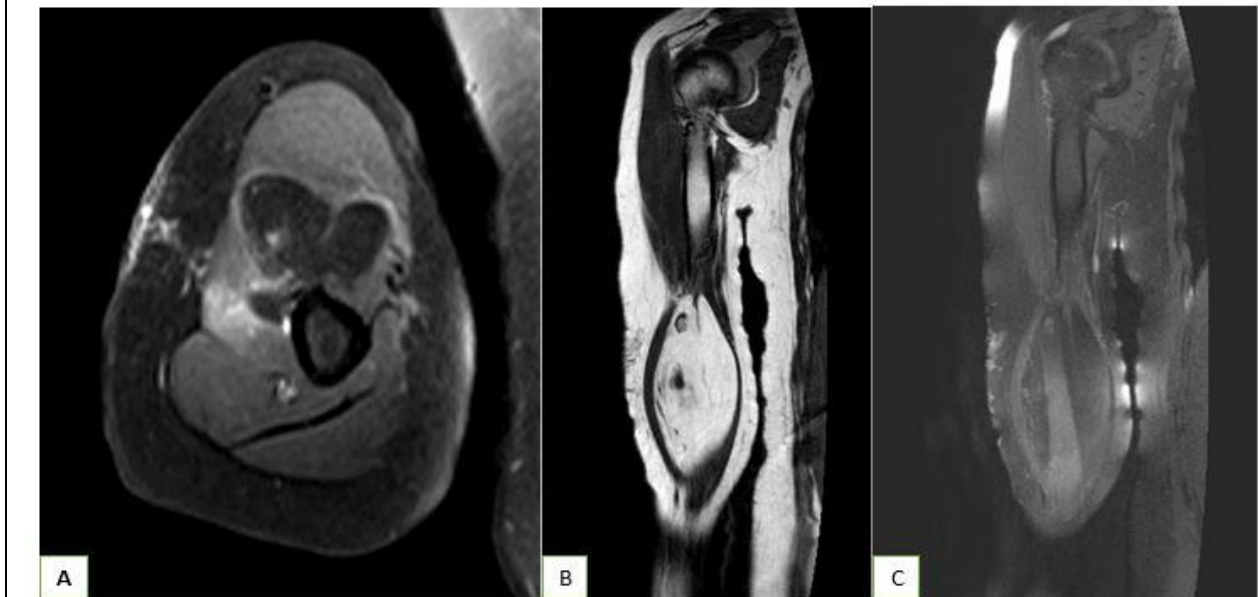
MRI Scan: Axial T2-weighted (A), Coronal T1-weighted (B), Coronal T2- weighted MR image with fat saturation (C) image of upper arm shows a septate mass with fat signal intensity in close proximity to the low-intensity cortical bone
